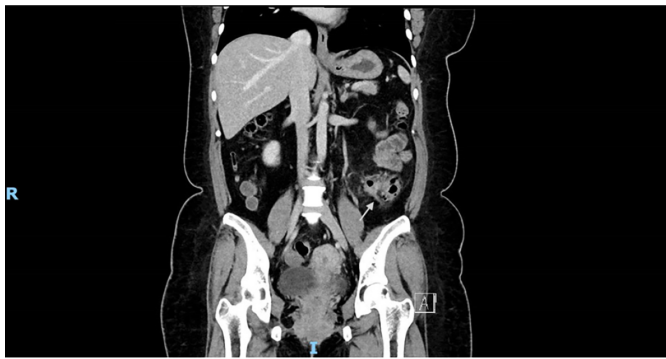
Computed tomography of abdomen pelvis coronal cut, showing signs of pericolic fat stranding and extraluminal air pockets fluid density with peritoneal thickening at the sigmoid colon, likely representing a sealed perforation.
